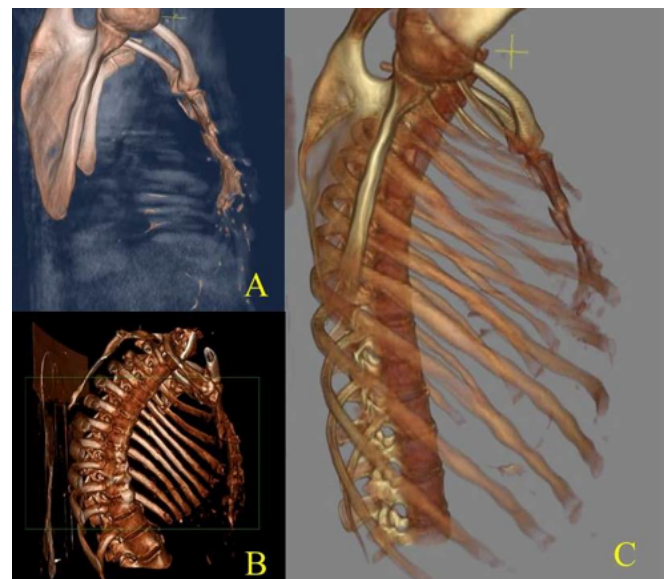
Three dimensional (3D) computed tomographic reconstruction views of sternal fractures. A. Ribs and thoracic vertebrae are extracted, B. Right hemi-thoracic structures are extracted, C. All bony structures are present.
